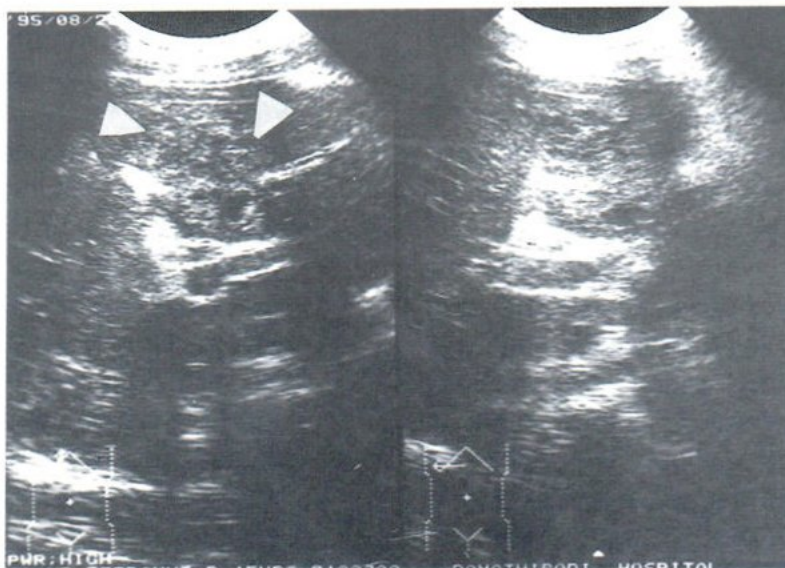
Sonogram taken 3 weeks later showed ill defined hypoechoic areas in the left lobe of the liver (arrowheads).
